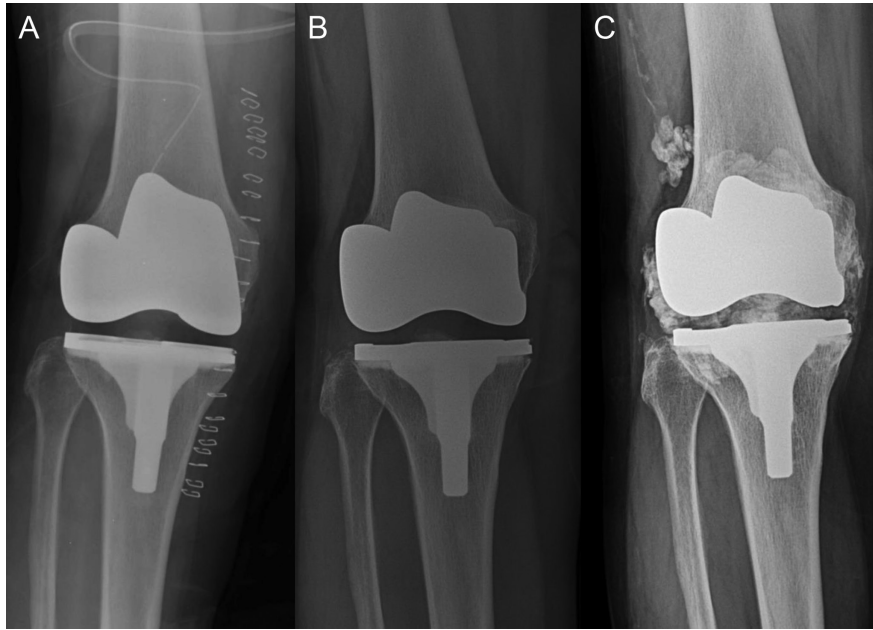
Serial postoperative anteroposterior radiographs (A) immediately, (B) at 5 years, and (C) 10 years following primary oxidized zirconium total knee arthroplasty.
